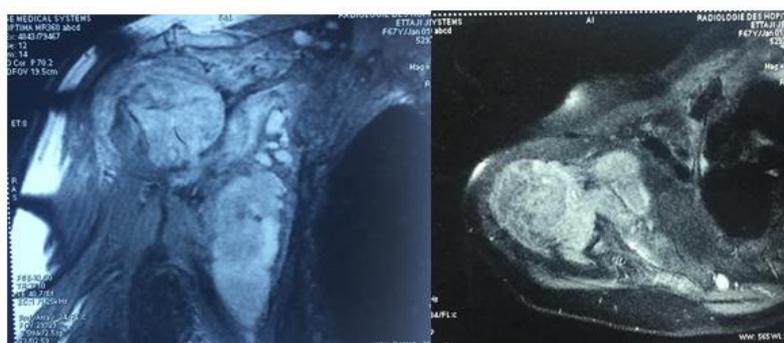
MRI of the right shoulder showing the lesion
